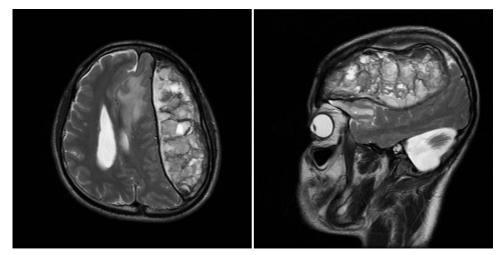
MRI scan of brain-chronic subdural haematoma, haemorrhagic contusions at left frontal lobe with surrounding vasogenic oedema, and absence of cerebral venous sinus filling defect on magnetic resonance venography.
